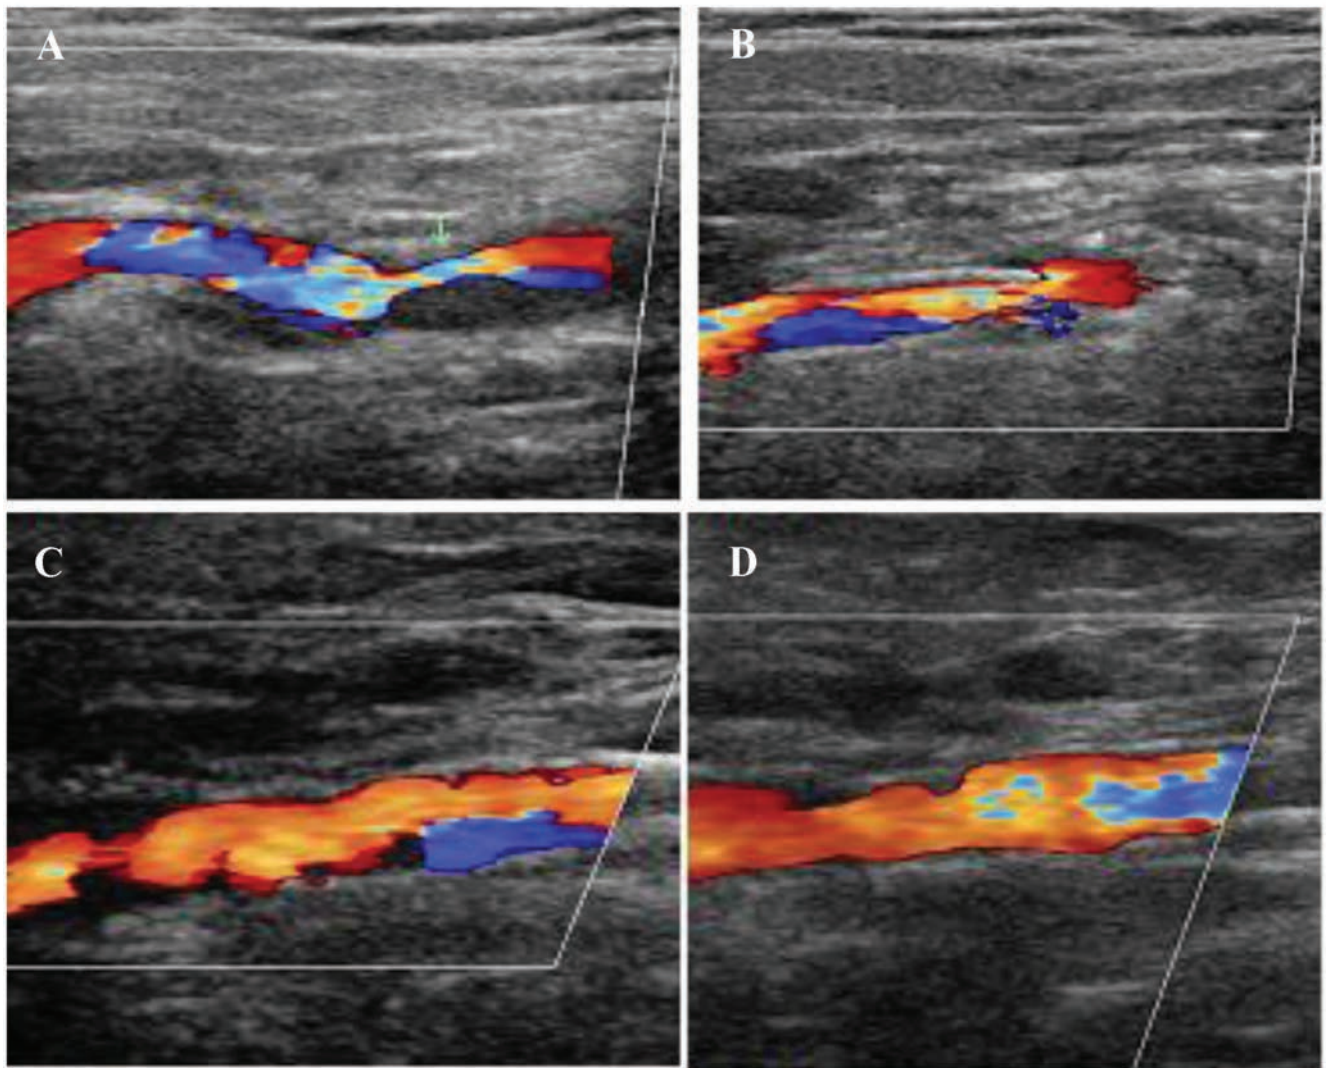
Duplex ultrasound images: A) pre-operative; B) post-operative day-1; C) post-operative day-3; D) post-operative day-30.
